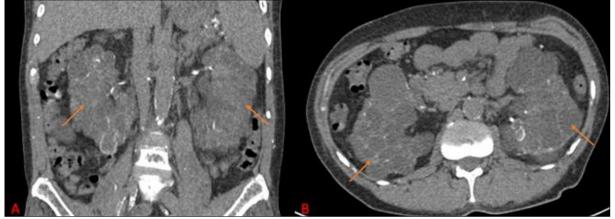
Abdominal CT scans in coronal (A) and axial (B) views using soft tissue window, showing polycystic kidney disease (orange arrow): enlarged kidneys with multiple cysts of varying sizes and shapes, some of which exhibit wall calcifications
